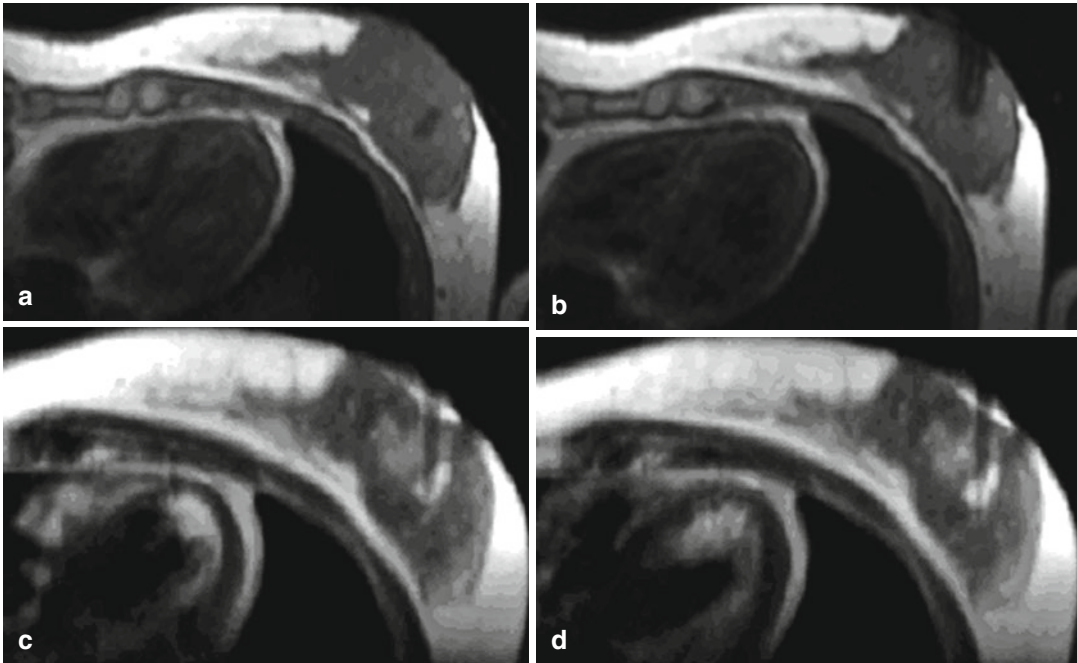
T1-weighted gradient-echo image without contrast agent depicts a breast lesion, which showed a pathologic fast uptake of contrast agent suggesting a malignant tumor (a). Using a T1-weighted gradient-echo sequence, the localization wire causes a susceptibility
